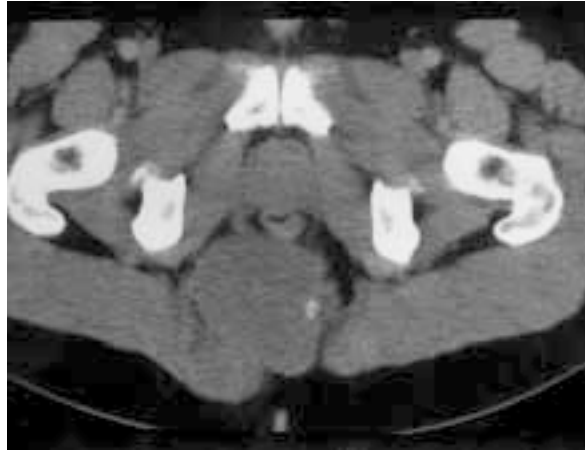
Enhanced axial CT taken through the level of the pelvic floor.
